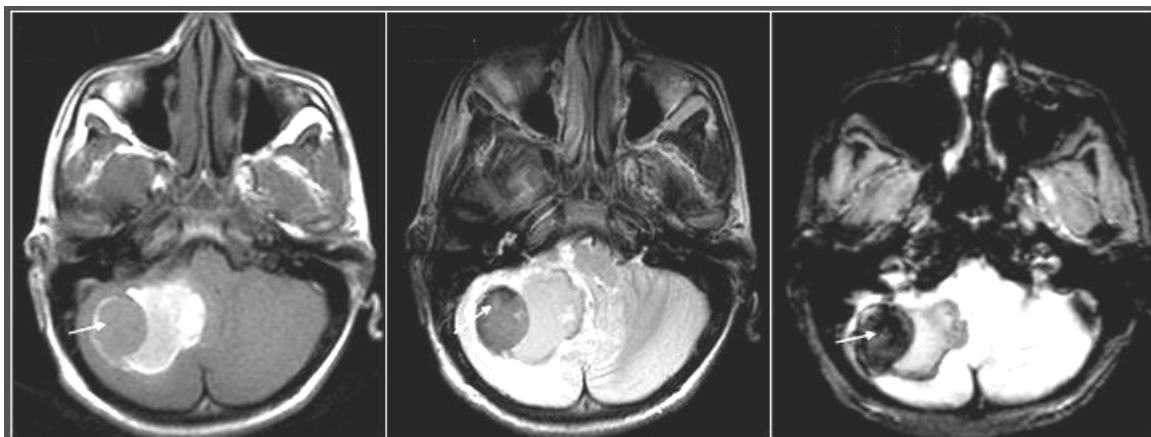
MRI exam – Intracerebellar hematoma evolution from subacute to chronic stage. Hematoma has a subacute constituent (medial) and a chronic constituent (pointer/lateral), with the chronic constituent both hypo-intense T1, and T2
